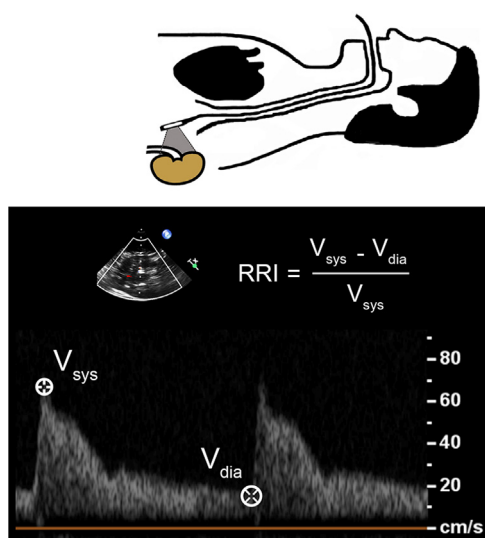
Calculation of the renal resistive index (RRI) using transesophageal echocardiography.  $V_{sys}$  = peak systolic velocity;  $V_{dia}$  = trough diastolic velocity.
